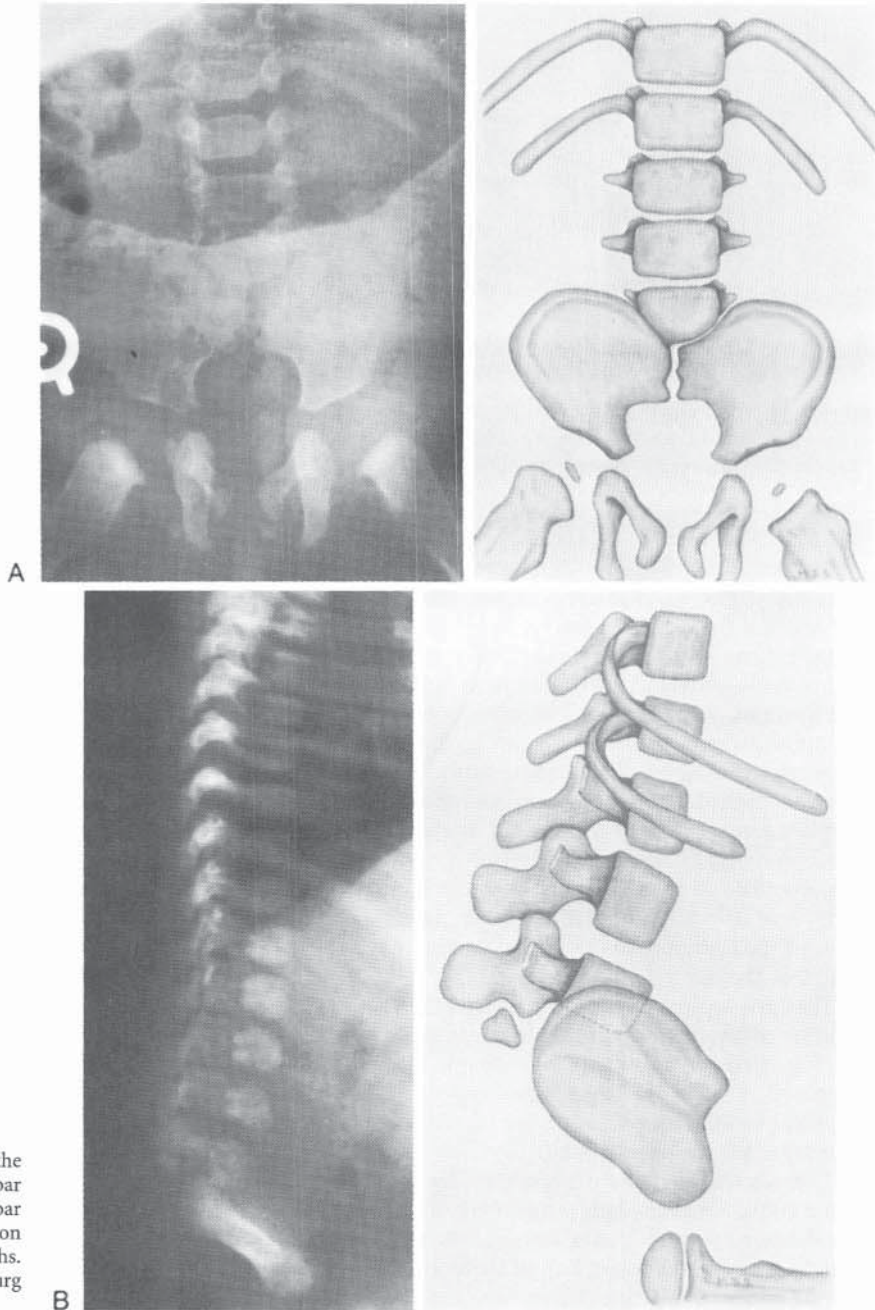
Type IV lumbosacral agenesis, the most severe type. The entire sacrum and lower lumbar spine are absent, and the articulation between the lumbar spinal remnant and pelvis is unstable. A, Appearance on AP radiographs. B, Appearance on lateral radiographs. (From Renshaw TS: Sacral agenesis. *J Bone Joint Surg* 1978;60-A:373.)
